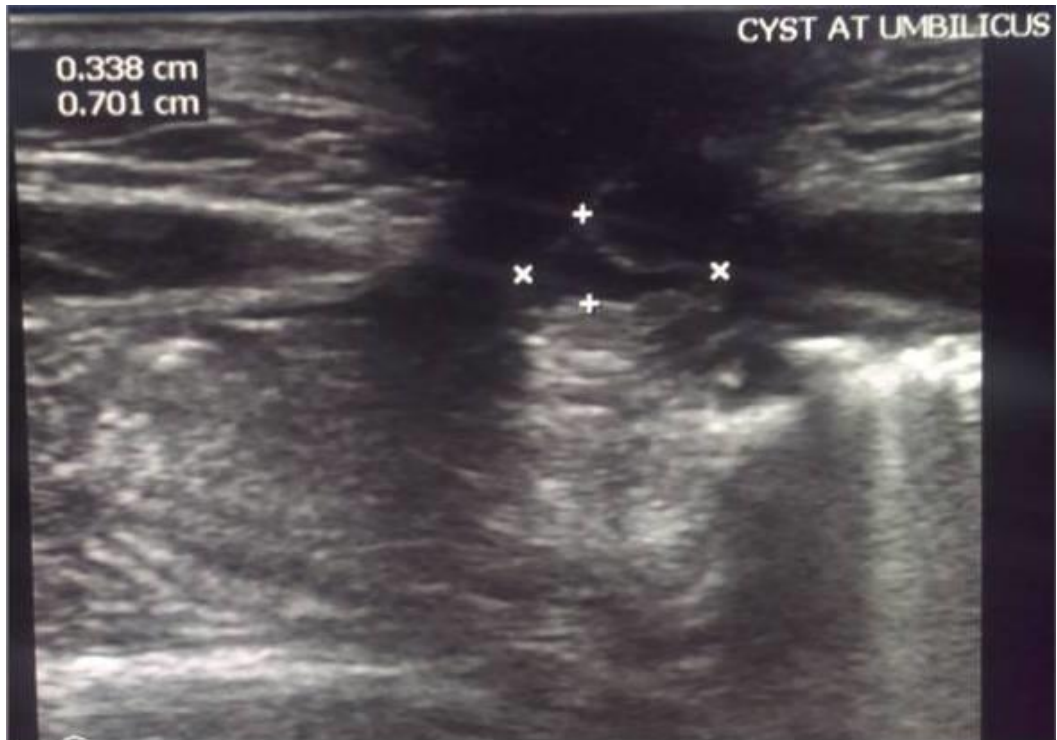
Ultrasound: Note a small 7x 3.4mm sized well defined cyst with thin and echogenic walls and with no obvious attachment to any intraperitoneal structure. The cyst is surrounded by debris.
